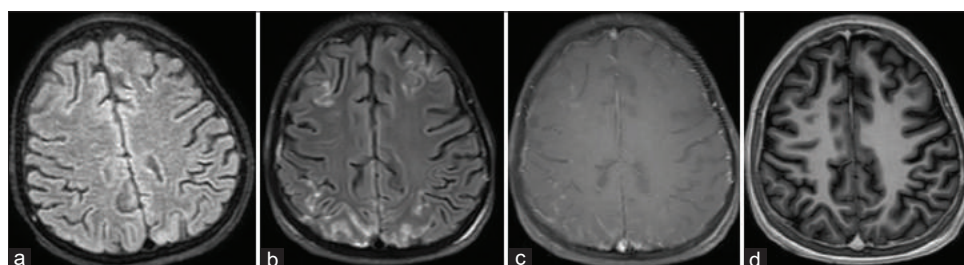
(a) Non-contrast fluid attenuation inversion recovery (FLAIR), (b) post-contrast FLAIR, (c) post-contrast T1W with magnetization transfer (MT), (d) axial reconstruction of 3D T1 magnetization prepared rapid gradient echo (MP-RAGE). In this case of meningitis, meningeal enhancement is clearly visible on post-contrast FLAIR and T1 with MT and not seen in T1 MP-RAGE.
